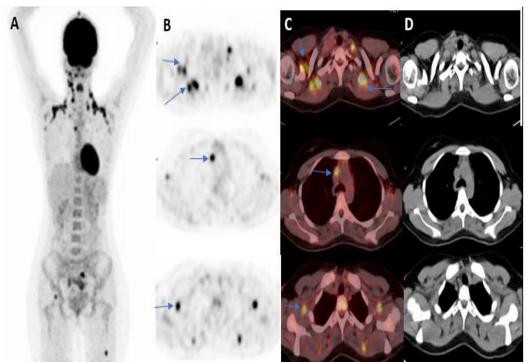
A 20-year-old female diagnosed with Hodgkin lymphoma, nodular lymphocytic predominant subtype (A), maximum intensity projection image shows moderate brown fat uptake in three regions (supraclavicular, mediastinal, and axillary regions); (B) transaxial PET images; (C) transaxial PET/CT fusion images. and (D) the corresponding CT reveals that 18F-FDG uptake is corresponding to fatty tissue (HU of -100).
